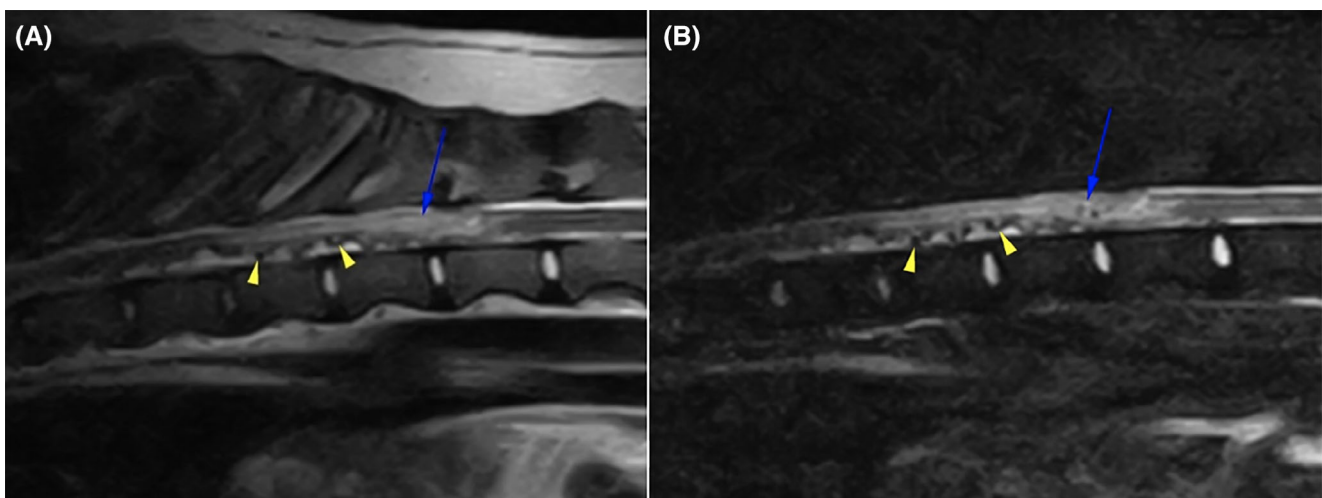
Sagittal T2-weighted, A, and sagittal short tau inversion recovery (STIR), B, magnetic resonance imaging (MRI) of the thoracic spinal cord. Distended subarachnoid vessels can be seen as multifocal, tortuous, signal voiding, tubular structures extending throughout the subarachnoid space (arrowheads). The nidus-type arteriovenous malformation (AVM) is visible at the level of T11 to T12 vertebral bodies (arrow)
